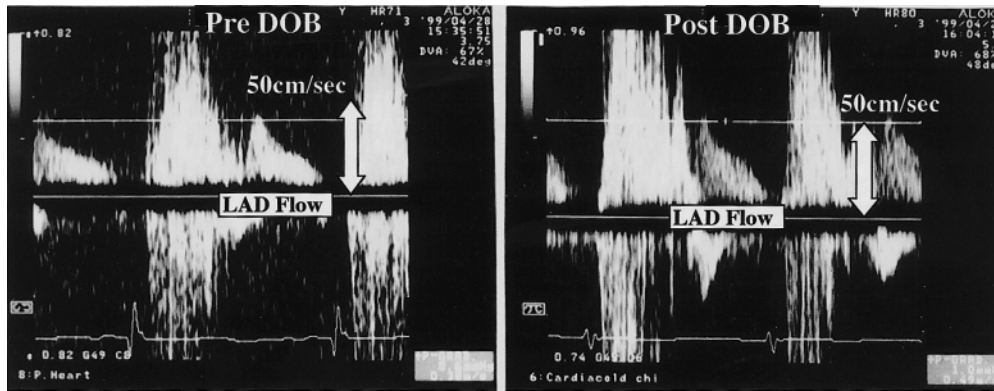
LAD flow velocity assessed by transthoracic echocardiography. Left side: pre Dobutamine infusion. LAD flow velocity is 38 cm/seconds. Right side: post Dobutamine infusion. LAD flow velocity is 50 cm/seconds.
